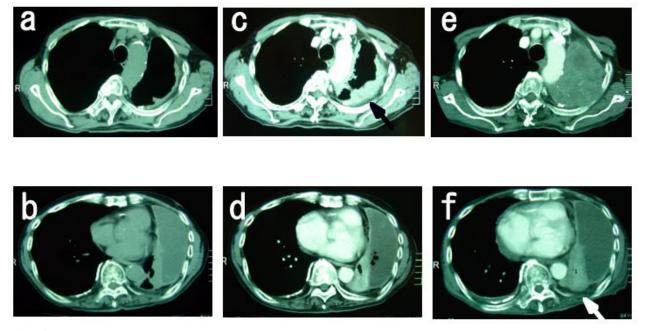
Serial images of chest CT scans. *a* and *b*: Non-contrast chest CT scans on the first visit show pleural thickening along the thoracic cage of the upper left lung with no involvement of the mediastinal side. A large empyema is seen in the lower left thoracic cavity with partial atelectasis of the lower lobe. Some calcifications are observed in the thickened pleura bilaterally. *c* and *d*: Contrast-enhanced CT scans on admission show increased irregular thickening of almost the entire circumference of the pleura involving both parietal and mediastinal sides. The increased size of nodular thickening along the dorsal part (arrow) is 1 cm greater than that in the chest CT scans from the initial visit. The empyema in the left thoracic cavity shows air bubbles probably due to the effect of aspiration cytology. *e* and *f*: Contrast-enhanced CT scans just before death show a fully consolidated upper lung. The size of the empyema is generally consistent but progressive nodular bulging is seen (arrow) in the lower left lung.
